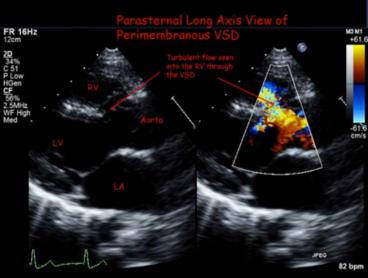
Echocardiography of a large perimembranous VSD. 2D and colour flow showing turbulent flow from left ventricle to the right ventricle of an eight-month old infant.
